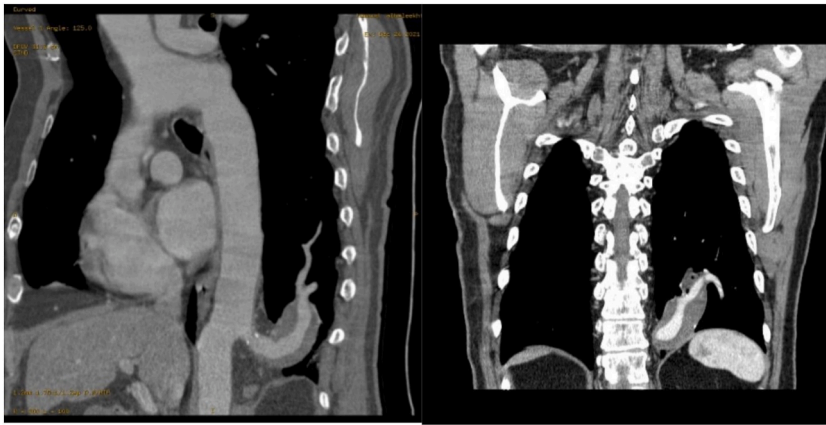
Coronal CT views showing the arterial blood supply from the descending thoracic aorta above the diaphragm.
